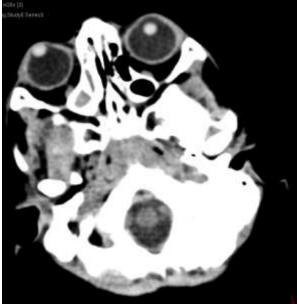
Plain CT brain revealed anterior dislocation of the right lens and a shallow anterior chamber.
